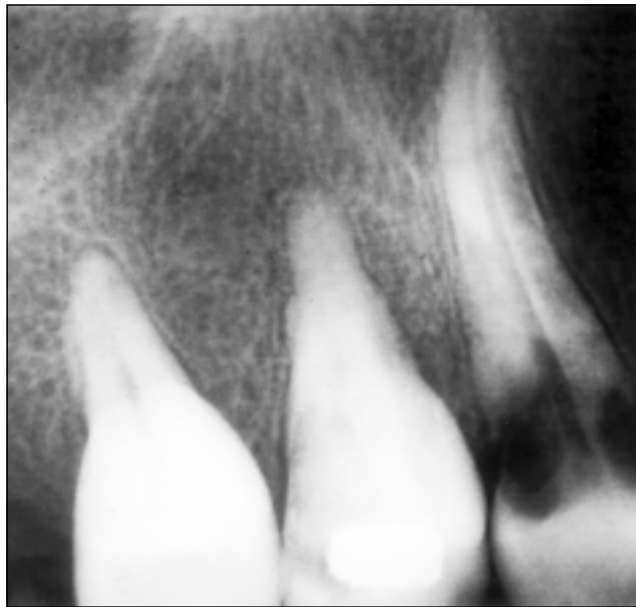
Maxillary periapical radiograph of patient A.
